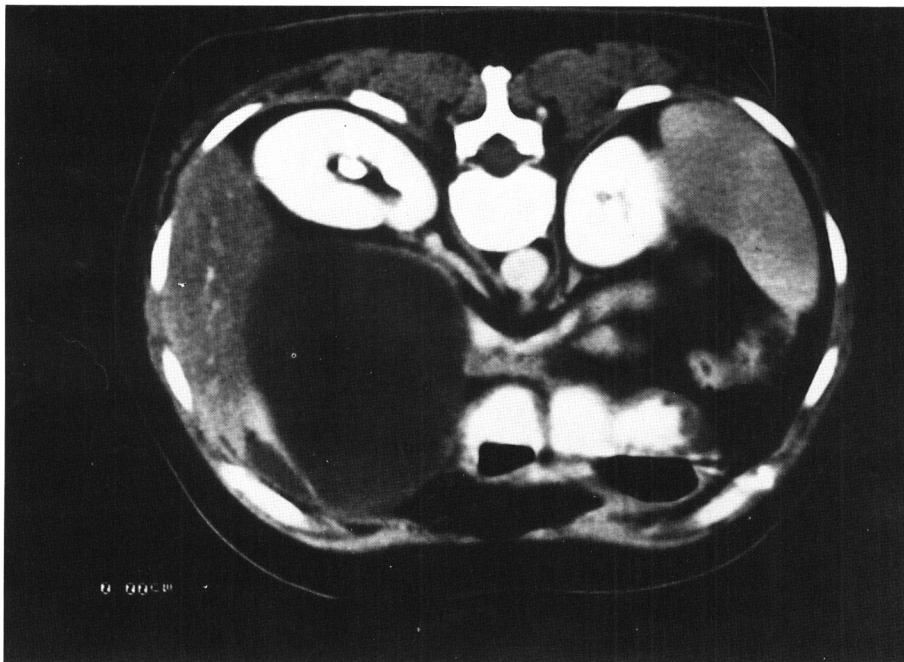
Abdominal CT scan showing a unilocular cyst in the head of the Pancreas.
